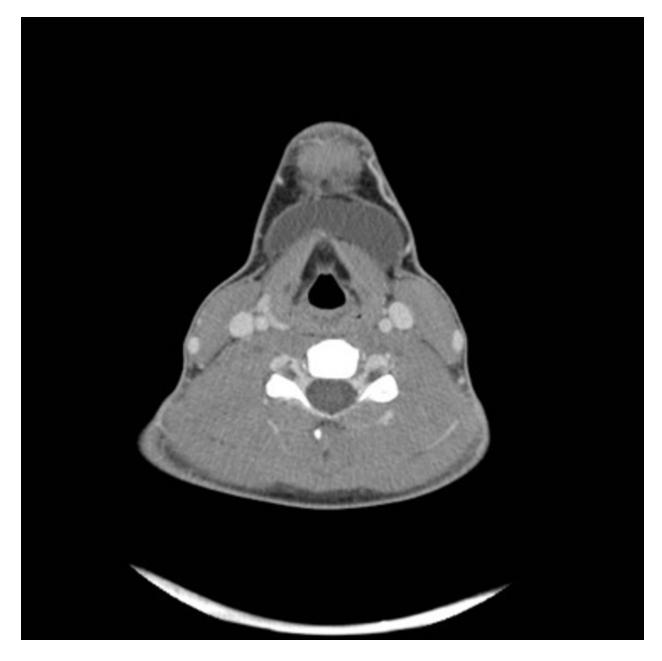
16-year-old boy with a thyroglossal duct cyst at the thyrohyoid level. Axial contrastenhanced CT image. A well defined cystic lesion with liquid density content.
